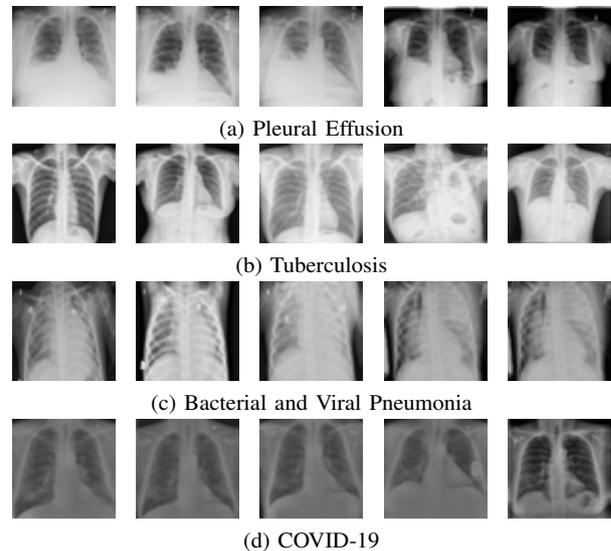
Sample chest radiographs
